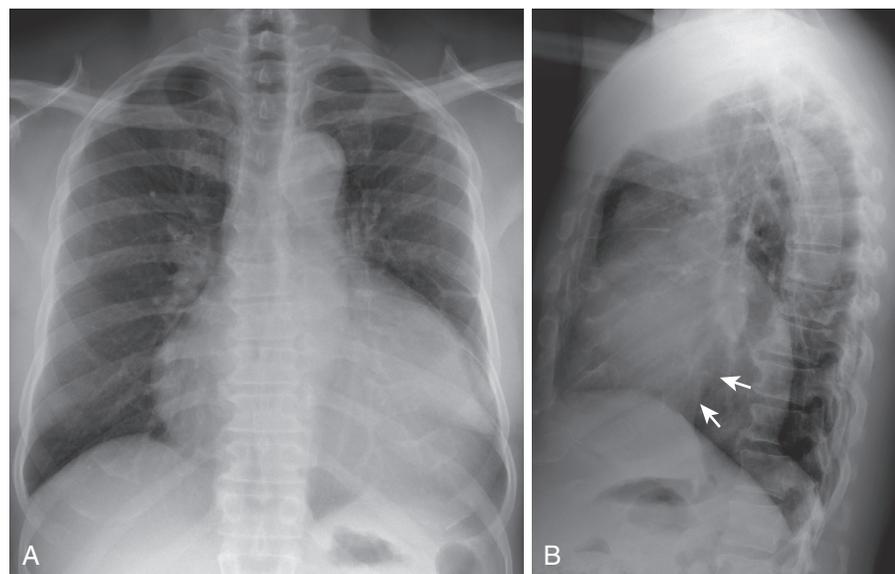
PA (A) and lateral (B) chest radiographs in a patient with a large pericardial effusion. The PA view reveals marked enlargement of heart with a hot water bottle shape. This can also have shape of an Erlenmeyer flask. The lateral view reveals the normal size heart (*arrows*) inside the pericardial effusion. Separation of epicardial from pericardial fat may be most apparent anteriorly.
